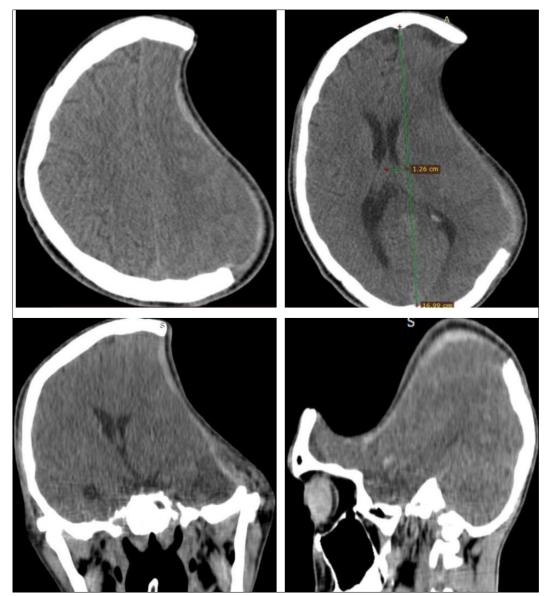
Cerebral CT scan at 45 days post-craniotomy, axial sections and coronal and sagittal reconstruction, parenchymal window: wide concavity of the overlying skin flap associated with fronto-parieto-temporal oedema responsible for a mass effect on the medial structures with subfalcoral involvement
